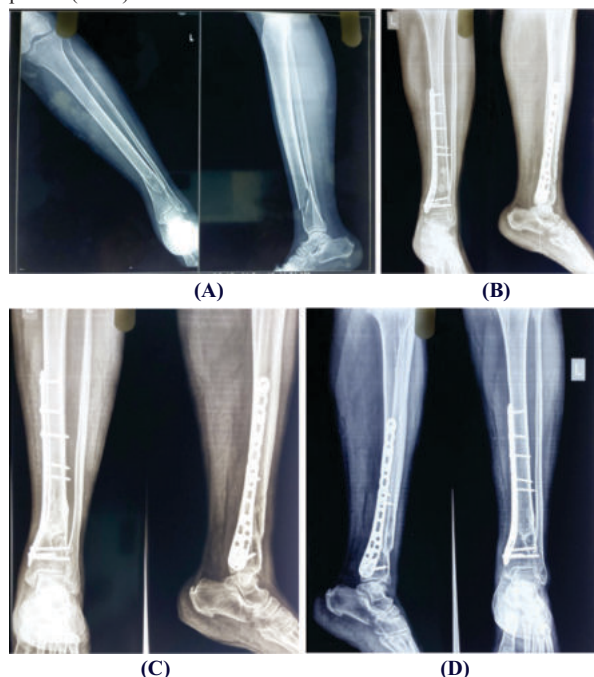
(A) Pre Op X-Ray , (B) Immediate Post Op X-Ray, (C) 6 Week Post Op X-Ray (D) 6 Months Post Op X-ray
